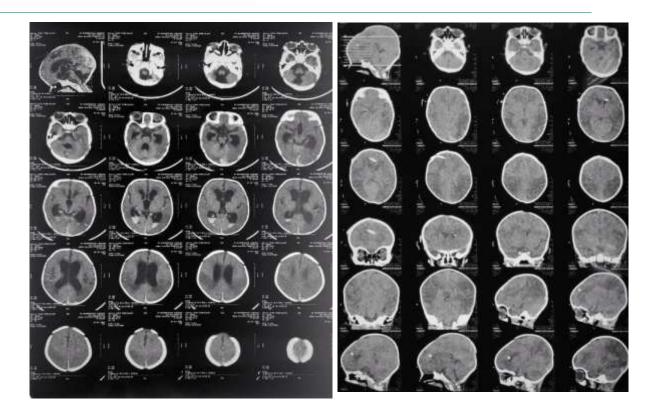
Head CT-scan, non-contrast (left 26/11/2022; right 4/12/2022)
